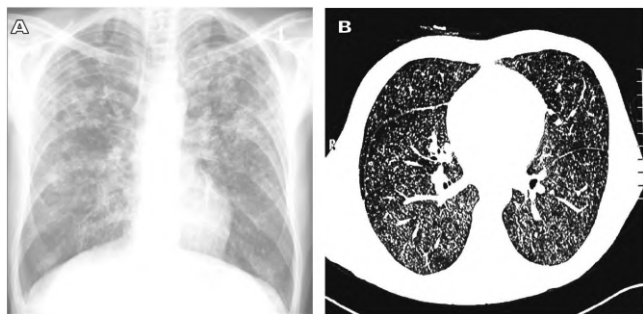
Chest X ray (A) showing increased bilateral lung markings with diffuse patchy infiltration. CT Scan (B) showing bilateral patchy infiltration with extension miliary nodules in both the lung fields
